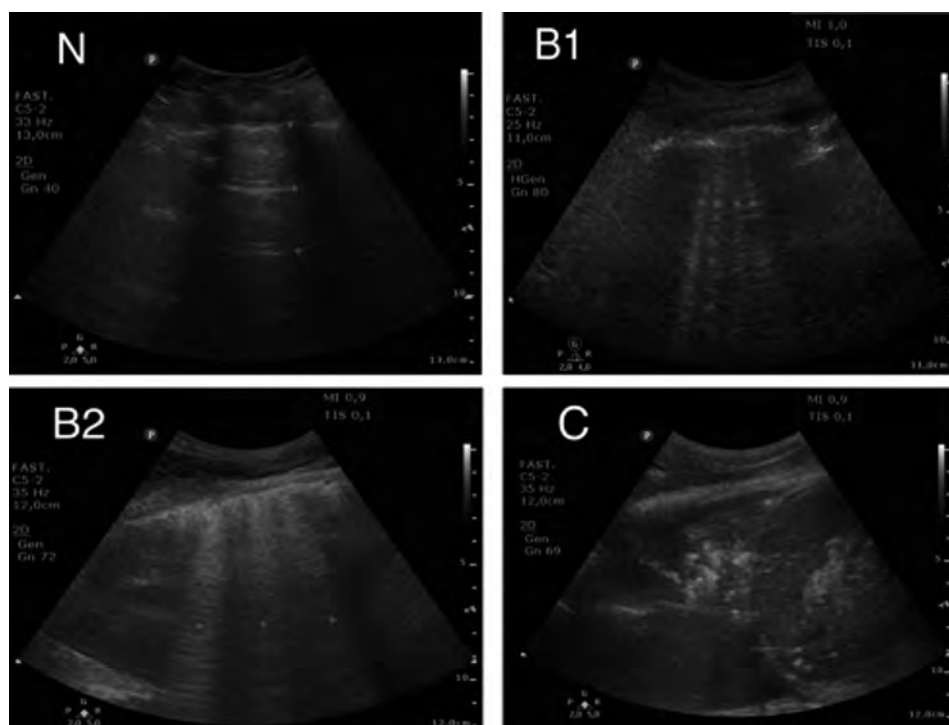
Lung ultrasound patterns, degree of lung aeration. N (properly aerated): the movement of the lung was clearly visible against the pleural cavity and A-line or single (< 3), narrow, and properly defined B-lines occur; B1 (moderately non-aerated, moderate interstitial syndrome): multiple (> 3), regular, and clearly visible B-lines, no A-line; B2 (alveolar-interstitial syndrome): diffuse B-lines, unclearly defined, occurring at uneven distances < 3 mm; C (consolidation): “lung hepatization syndrome” with air or fluid bronchogram, no A-line or B-line, impaired movement of the lung against the pleural cavity
